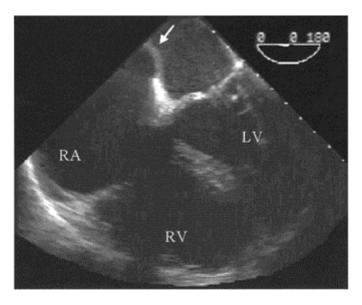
Transesophageal, fourchamber view of a patient suffering cardiac arrest secondary to massive pulmonary embolism. Note the dilated right atrium (RA) and right ventricle
